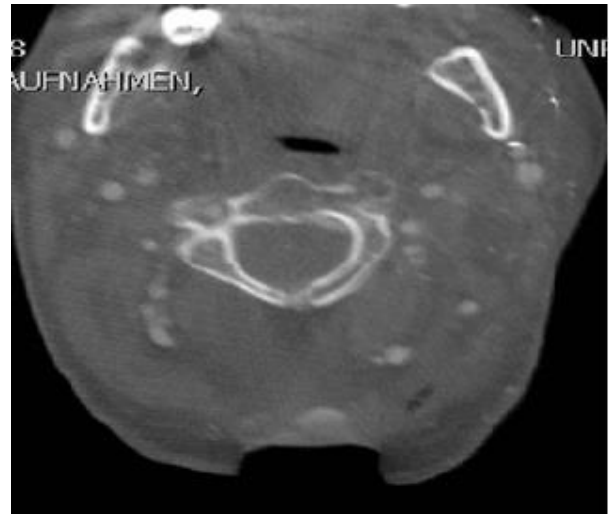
Intraoperative CT Navigation with contrast, performed with O-Arm, where dissection of the left vertebral artery is still visible
